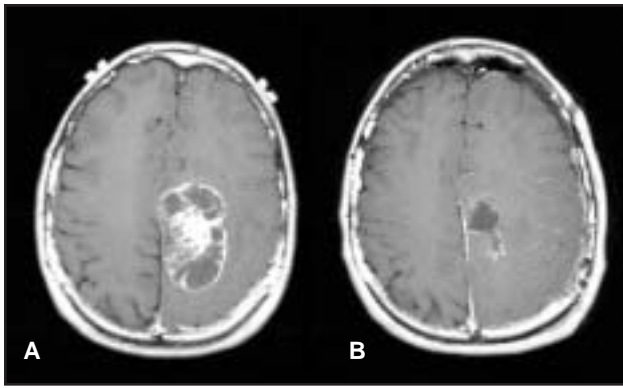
(A) Preoperative and (B) postoperative contrast-enhanced MRI images demonstrating complete resection of a glioblastoma.
